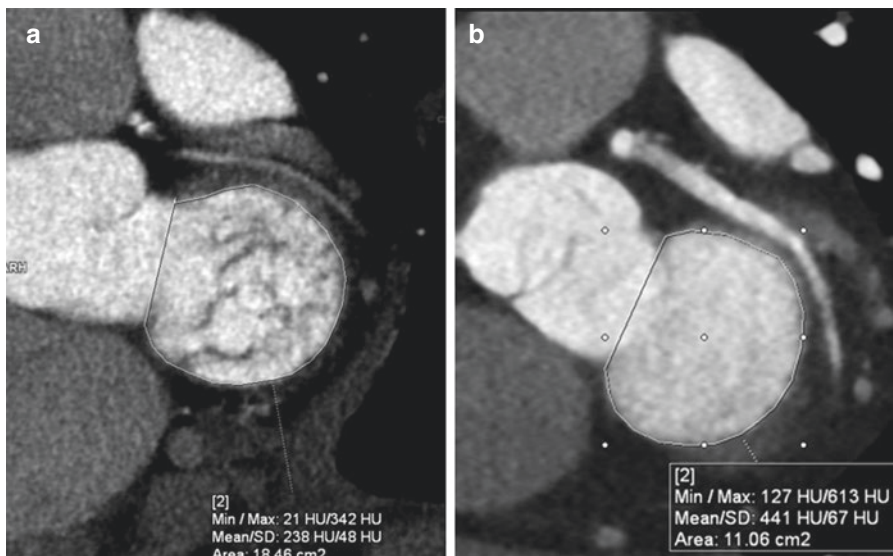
Cardiac computed tomography assessment of the mitral valve annulus. The annulus on the right-sided image is normal in dimensions and shape, whilst the annulus on the left-sided image is dilated and circularly remodelled with increased antero-posterior diameter (Barlow Disease). (Image courtesy of Dr. Jonathan WeirmcCall, Royal Papworth Hospital)
